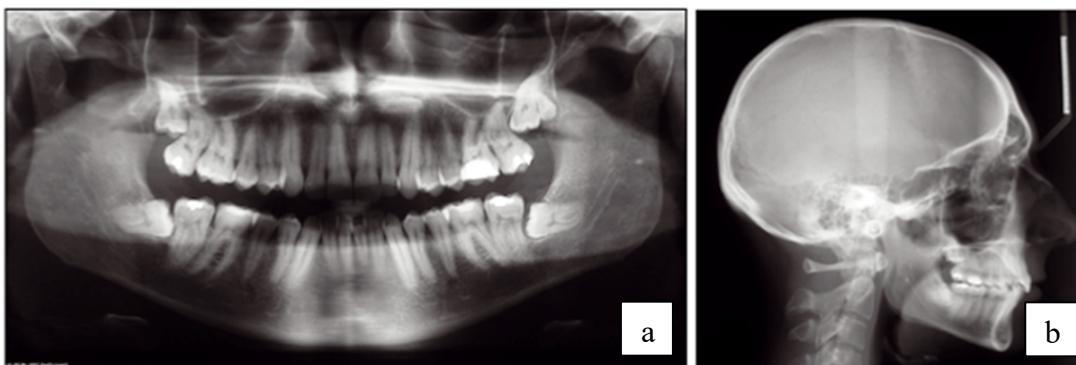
a) Orthopantomography. b) Profile cephalometric Xray
